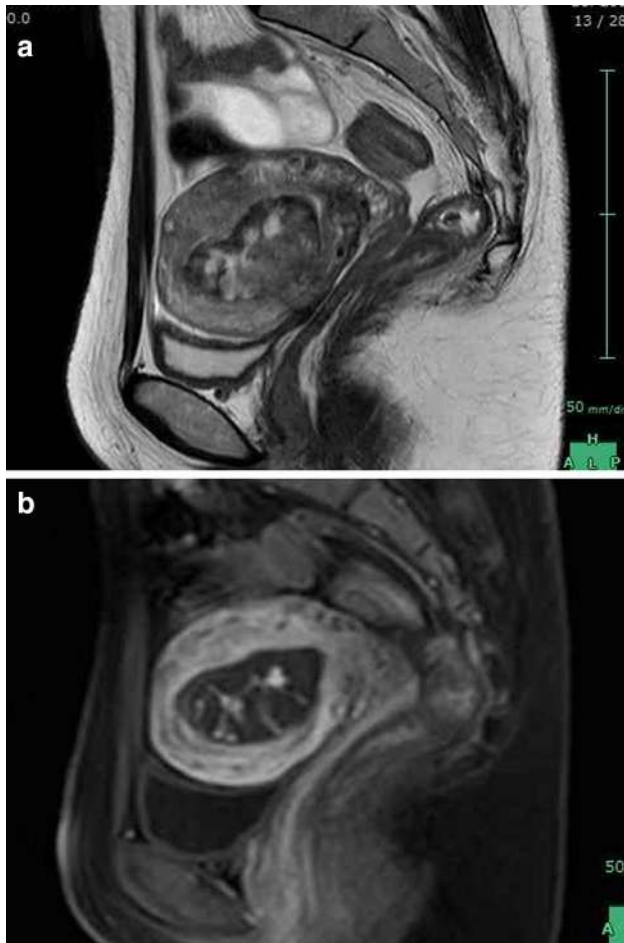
35-year-old woman with massive genital bleeding 7 weeks after dilation and evacuation (D&E) for anencephaly at 13 weeks' gestation. a MRI shows a heterogeneous mass protruding into the endometrial cavity with both high and low signal intensity on T2-weighted imaging. b Gadolinium-enhanced (Gd+) fat-saturated T1-weighted imaging reveals slight mass enhancement. Repeat D&E was successfully performed, confirming the diagnosis of retained products of conception
